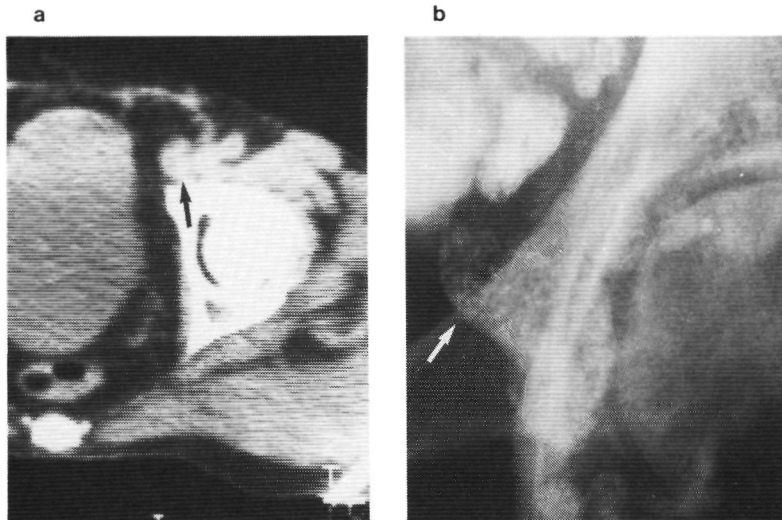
Left-sided inguinal nodes (arrows) of 13 mm diameter, with CT interpreted as normal (2a). Lymphomatous appearance at lymphography (2b).
